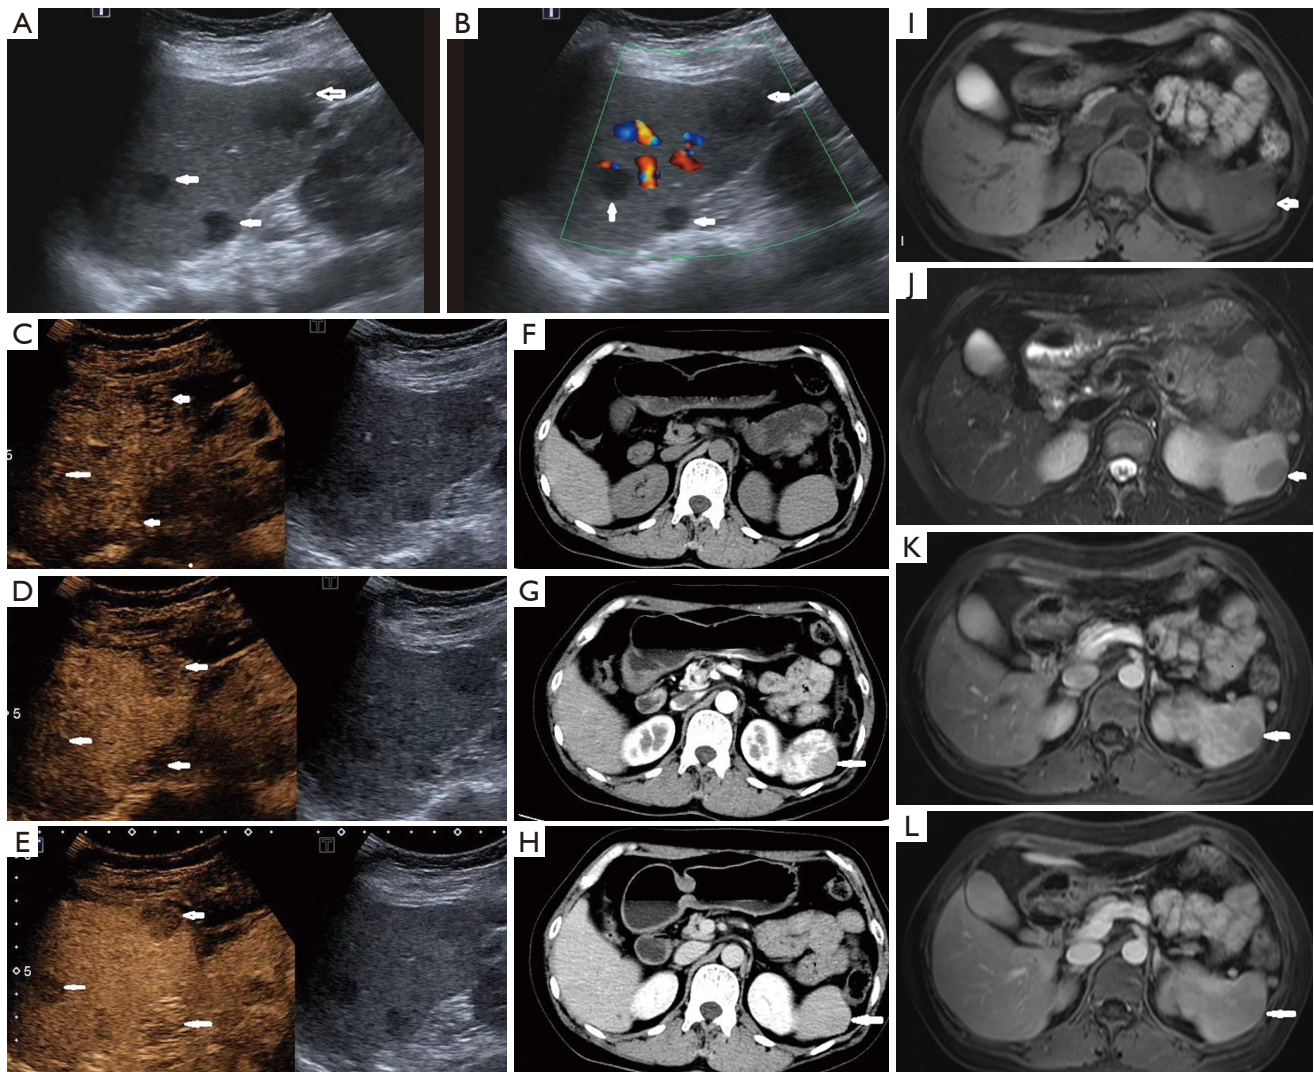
Inflammatory pseudotumor (IPT)-like follicular dendritic cell sarcoma (FDSC) imaging features of spleen with small mass. (A,B) In this case, 3 lesions (1.5, 1.7, and 2.9 cm in diameter, respectively) with homogeneous hypoechoic were found using two-dimensional ultrasound (A, arrows), and there was no blood flow signal in color Doppler flow imaging (B, arrows). (C-E) Contrast-enhanced ultrasonography showed isoechoicity shortly after contrast administration (15 s) (C, arrows), which returned to hypoenhancement in the arterial phase (26 s) (D, arrows). The tumor mass is still hypoechoic on the delayed-phase ultrasound images (E, arrows). (F) Abdominal plain computed tomography (CT) scan did not find any obvious abnormalities in the spleen. (G,H) Contrast-enhanced CT showed a well-demarcated, hypointense lesion in the lower pole of the spleen (arrows). (I,J) Three well-defined hypointense lesions were detected on both T1- and T2-weighted magnetic resonance imaging (MRI) (arrows). (K,L) Contrast-enhanced T1W MRI showed the lesion without obvious enhancement in contrast to the significantly enhanced spleen parenchyma (arrows).
